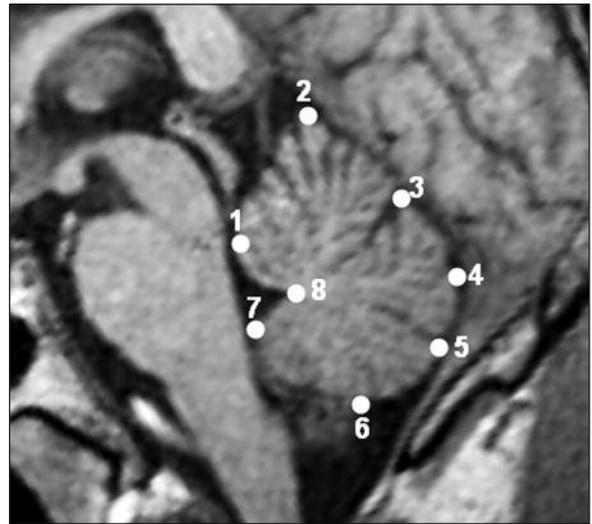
T1-weighted mid-sagittal slice demonstrating the cerebellar landmarks.
